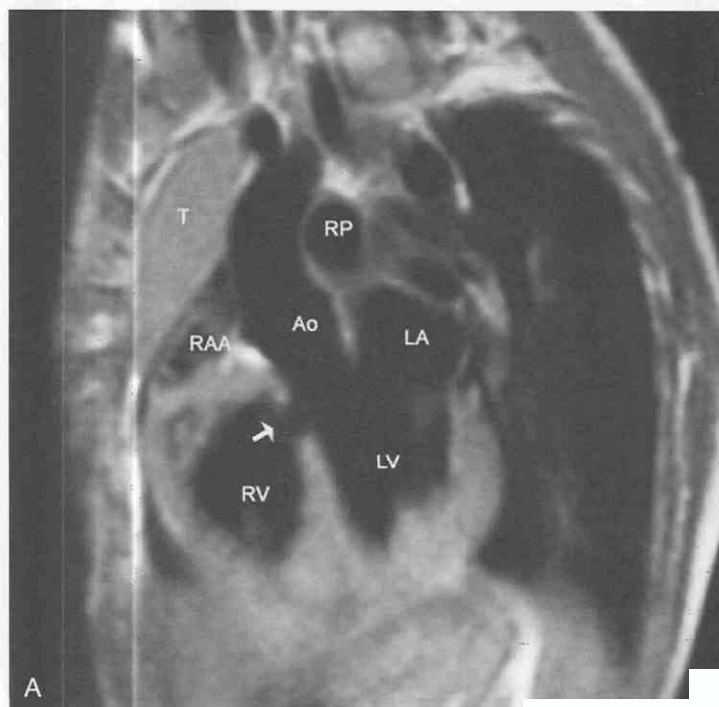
MR images obtained from a 5-year-old boy with a muscular ventricular septal defect. *A*, Oblique sagittal spin-echo acquisition through the aortic root (Ao). The defect (arrow) is well away from the membranous interventricular septum and the aortic annulus. LA, left atrium; RAA, right atrial appendage; RP, right pulmonary artery; RV, right ventricle; T, thymus. *B*, Systolic axial gradient-reversal acquisition through the defect shows the fan-shaped signal void jet (arrows) extending from the dilated left ventricle (LV), through the septum, and into the right ventricle (RV). LA, left atrium.
